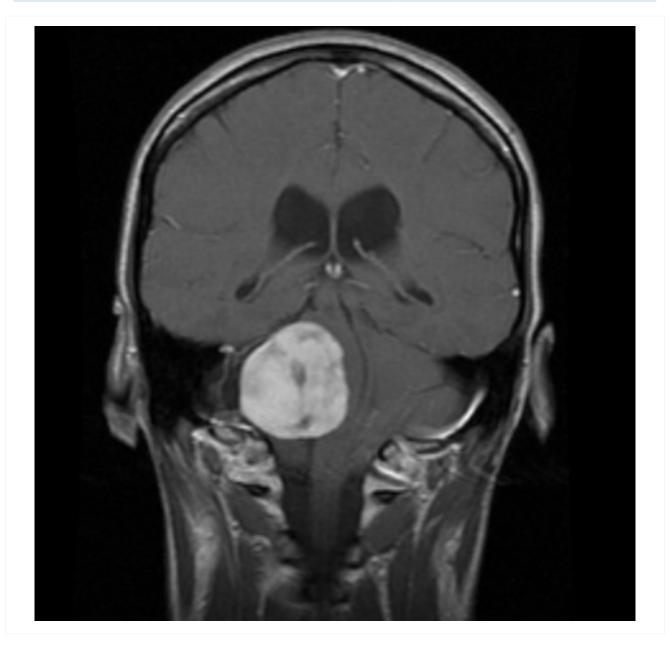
Acoustic neuroma: coronal postcontrast MRI
